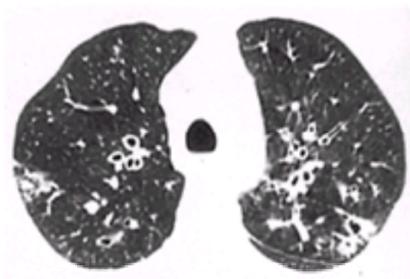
Young's syndrome with bronchiectasis documented by high-resolution computed tomography showing bilateral bronchiectasis.
